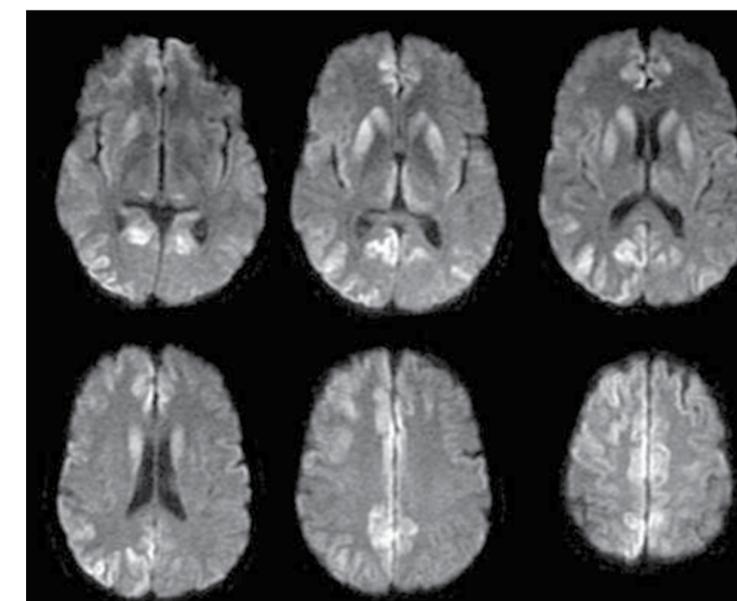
Typical magnetic resonance image (MRI) findings in sporadic Creutzfeldt-Jakob disease (sCJD). Typical diffusion-weighted MRI abnormality in a patient diagnosed with sCJD demonstrates an increased signal in bilateral medial frontal, parietal, and occipital cortices and deep gray matter (particularly the bilateral caudate and putamen).
